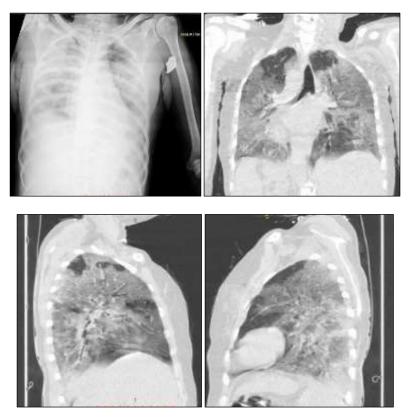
50 yr. old male, characterized as severe on CXR as well as CT. CXR (AP-view); coronal, right sagittal and left sagittal HRCT (from top right then clockwise)
